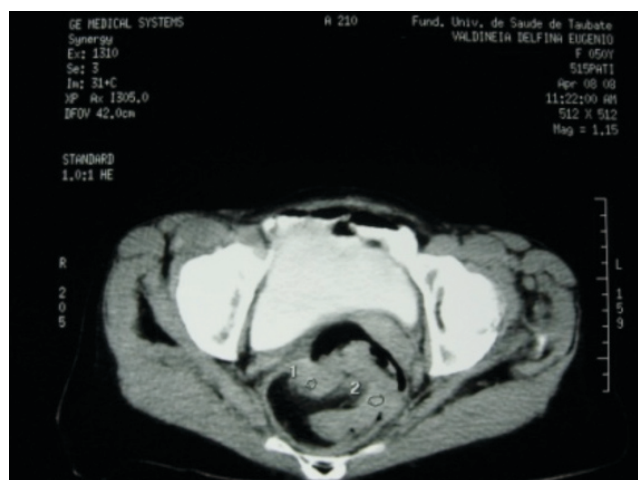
Pelvic computed tomography showing lesion in the rectal region (target image).
